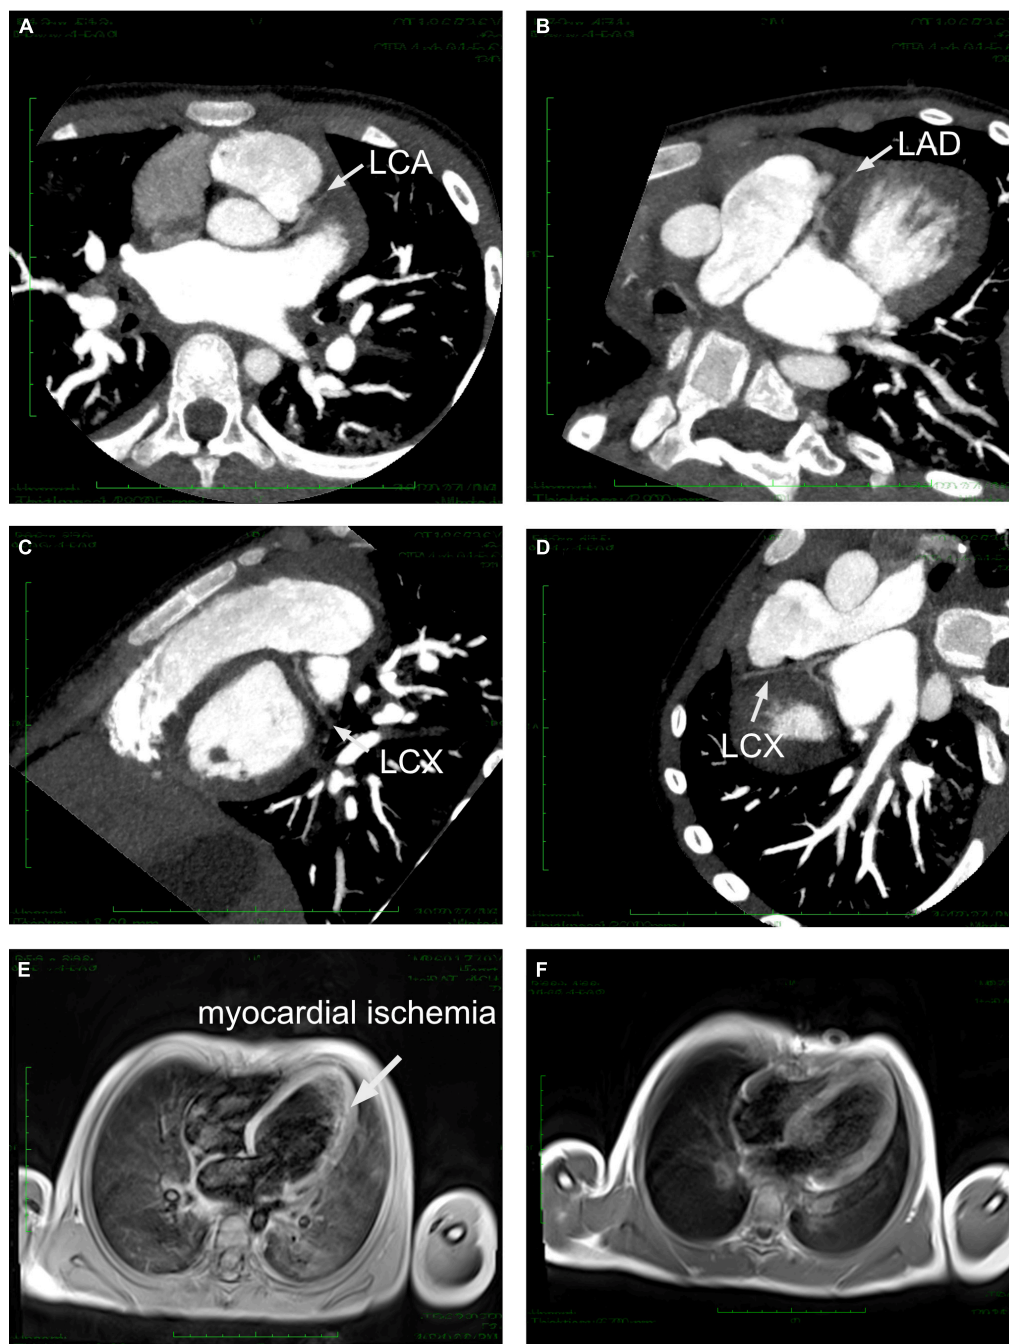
Cardiac CTA and MRI imaging. (A) Left coronary artery originated from an abnormal location at the superior and posterior sites in the left coronary sinus. (B–D) LAD and LCX demonstrated severe dysplasia under several sections of CTA. (E) Cardiac MRI demonstrated significant myocardial ischemia and fibrosis in the left ventricular wall before surgical correction. (F) Cardiac MRI image after surgical correction revealed a normal perfusion. LCA, left coronary artery; LAD, left anterior descending; LCX, left circumflex.
